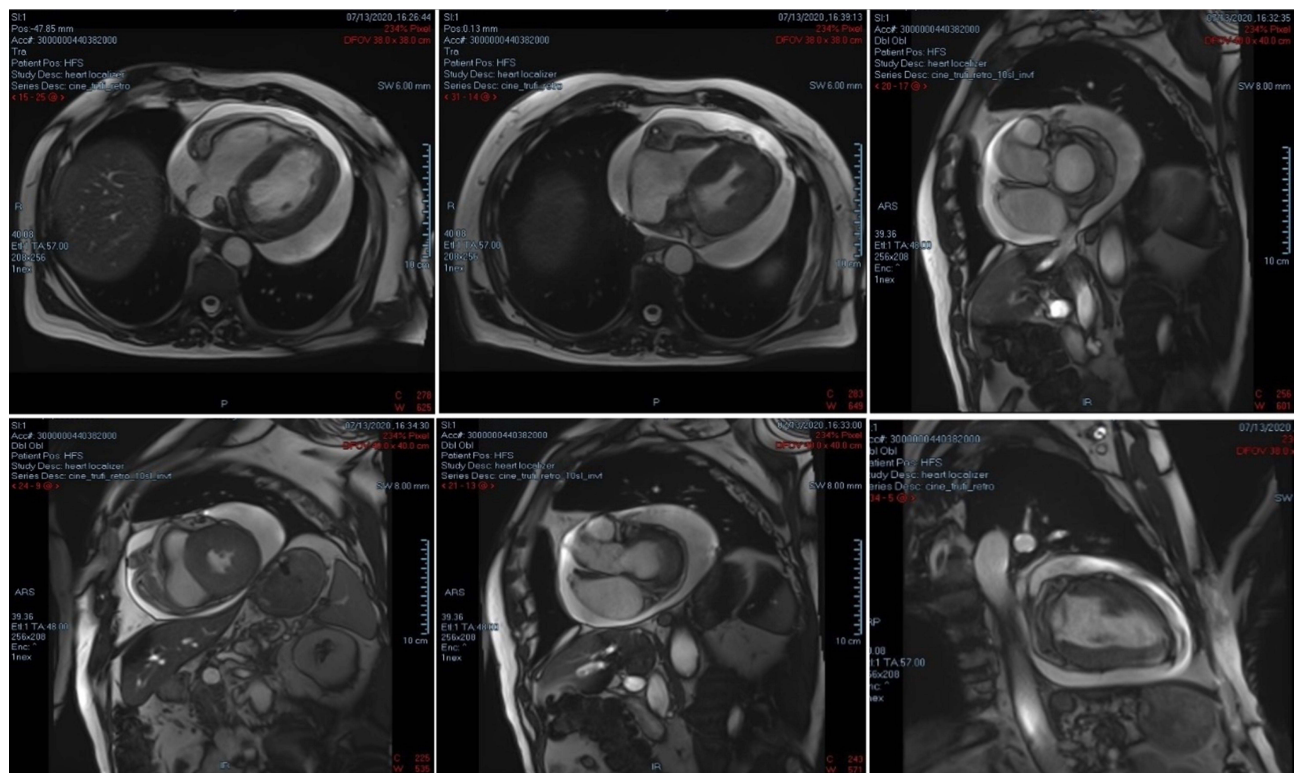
Cardiac magnetic resonance imaging in cine T2 sequences demonstrating the pericardial mass in different slices.
